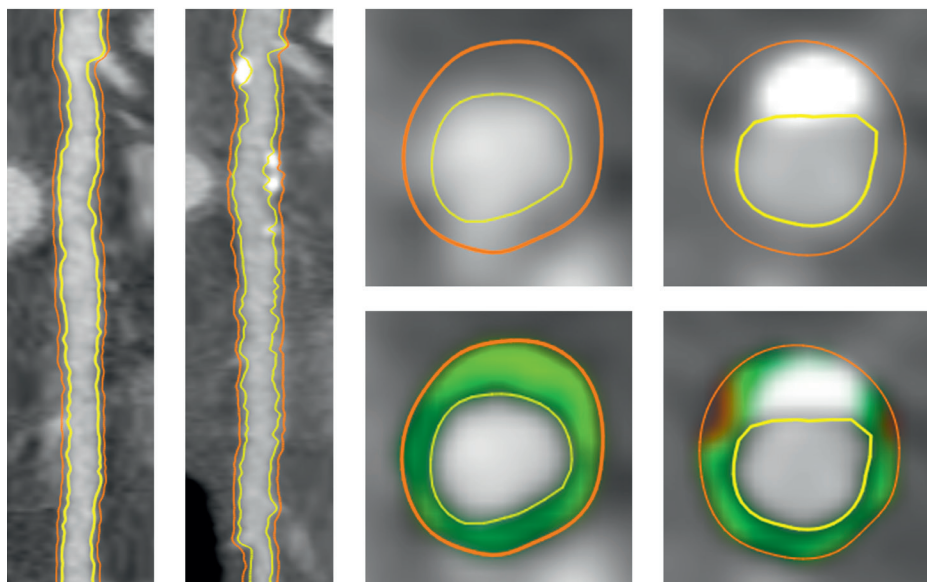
Example of quantitative CTA analysis for a statin-taking patient. Representative case showing the impact of statin use on CAD progression. Although initially no coronary calcification was present at quantitative CTA analysis, extensive calcification had occurred after 8 years of follow-up. Red indicates necrotic core tissue, light green indicates fibro-fatty tissue, dark green indicates fibrous tissue and white indicates dense calcium tissue. CAD = coronary artery disease; CTA = computed tomography angiography.
